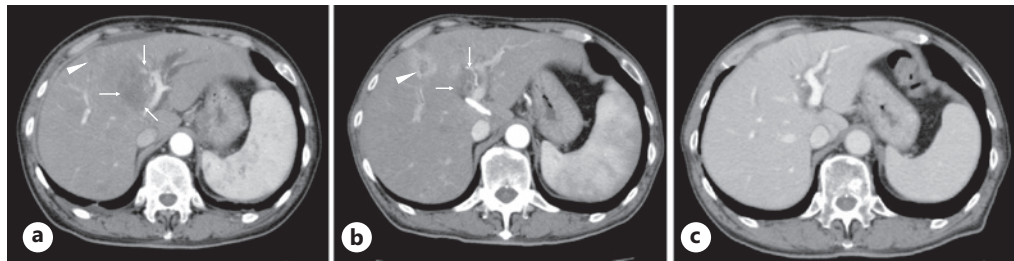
Computed tomography (CT) findings over time. CT on admission showed an ill-defined large tumor (arrows) adjacent to the umbilical portion of the portal vein and a small lesion (arrowhead) near the liver surface (a). CT 3 (b) and 12 months (c) after biliary drainage showed marked and complete regression of the tumors, respectively.
